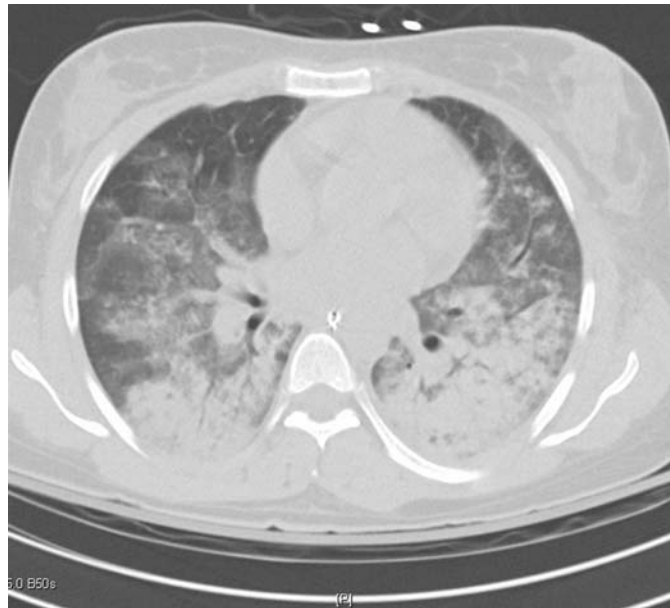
FIGURE e24-29 CT scan of ARDS demonstrates ground-glass infiltrates with more consolidated areas in the dependent lung zones.
